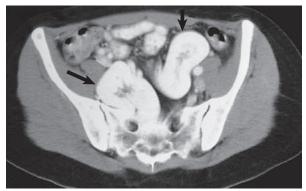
Bilateral pelvic kidneys (arrows) on CT.
